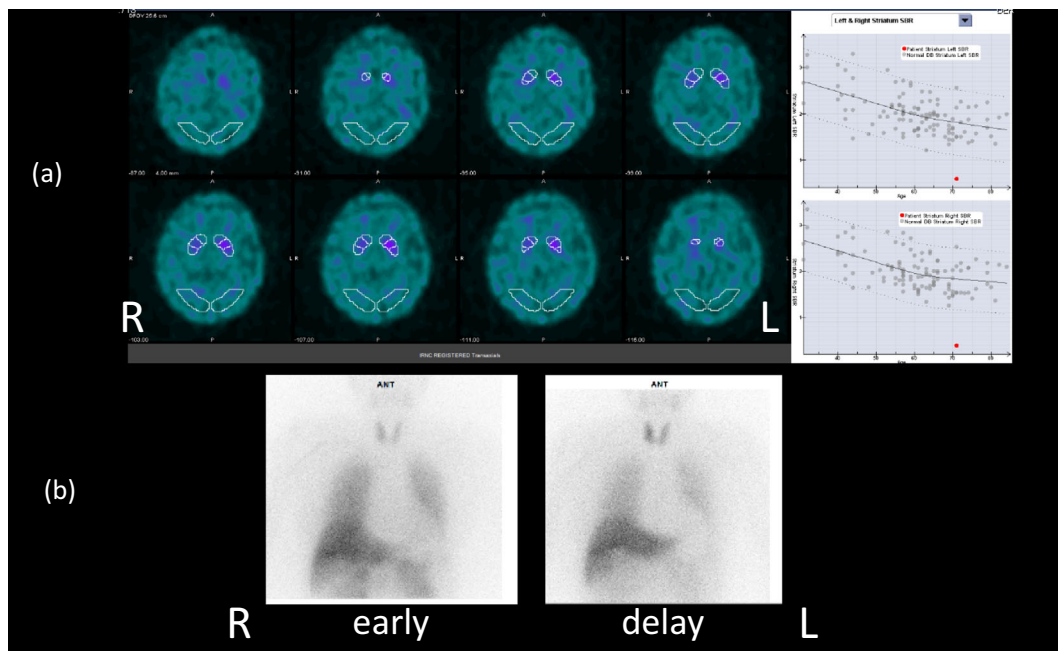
$[^{123}\text{I}]\text{-}2\beta\text{-Carbomethoxy-}3\beta\text{-(4-iodophenyl)-N-(3-fluoropropyl)}$ nortropone (FP-CIT) single-photon emission computed tomography (SPECT) and meta-iodobenzylguanidine (MIBG) myocardial scintigraphy. (a) FP-CIT SPECT images showed that the striatal uptake ratio was 0.39 (normal range 1.83 ± 0.33) in the right striatum and 0.58 (normal range 1.81 ± 0.35) in the left striatum using DaTQUANTTM, indicating a reduced striatal uptake. (b) MIBG myocardial scintigraphy showed that the heart-to-mediastinum (H/M) uptake ratio was 1.79 in the early phase and 1.44 in the late phase (normal H/M uptake ratio ≥ 2.2), indicating a reduced cardiac uptake.
